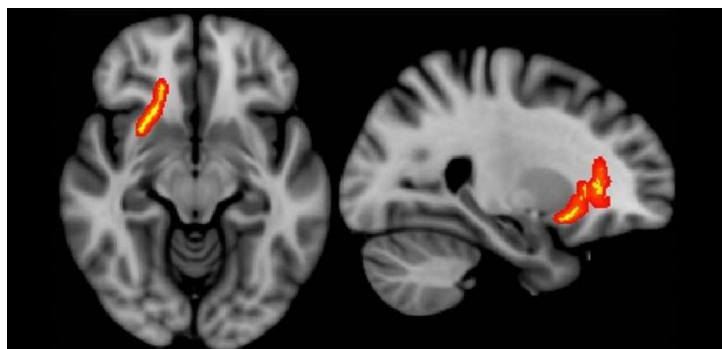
MRI shows brain disruption in children with PTSD
